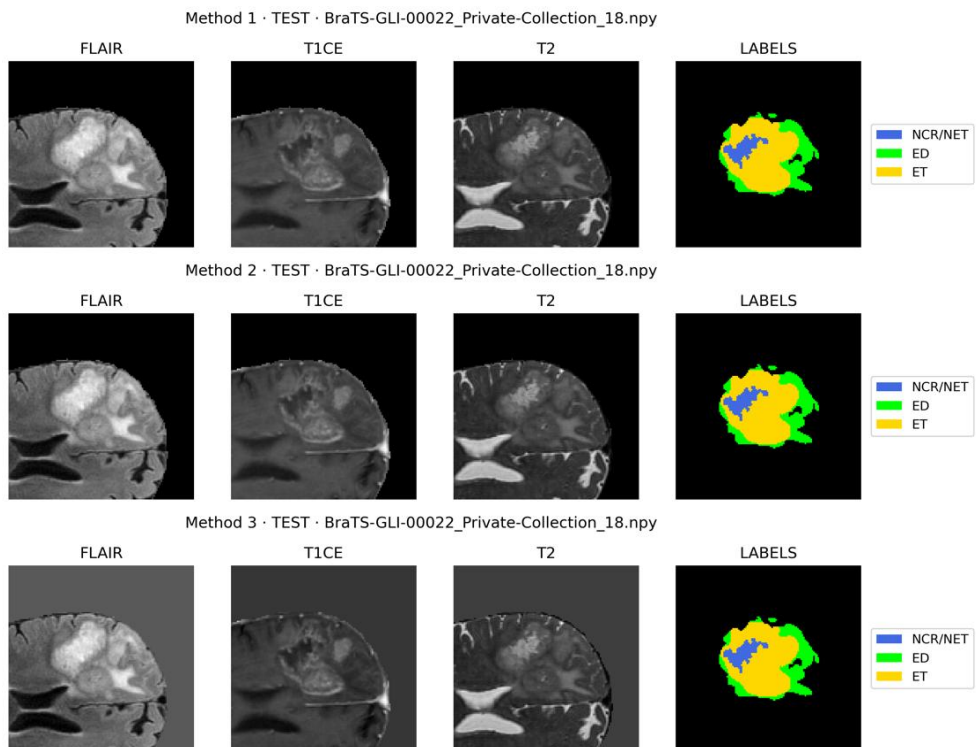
Images from the test set after preprocessing with Methods 1, 2, and 3. Each row shows FLAIR, T1GD, and T2 with the corresponding segmentation labels.
